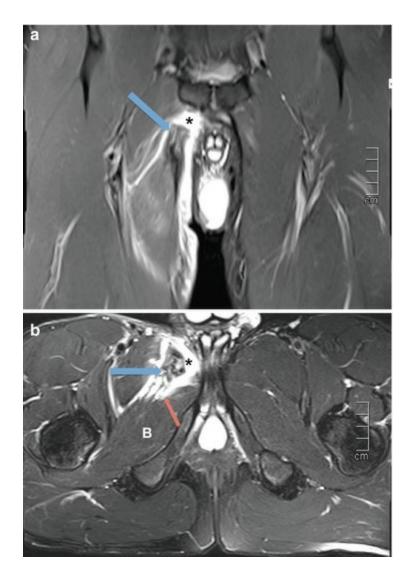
A 21-year-old male athlete with avulsion tears to the right adductor longus (AL) and brevis muscles. (a) Coronal and (b) axial short tau inversion recovery MRI show complete discontinuity with retraction of the proximal attachment of the right AL (*blue arrow*) surrounded by fluid, consistent with hemorrhage (*asterisk*). In the axial image, the tendon rupture appears to involve the adductor brevis (b), as suggested by the irregularity of its anterior surface (*red arrow*)
